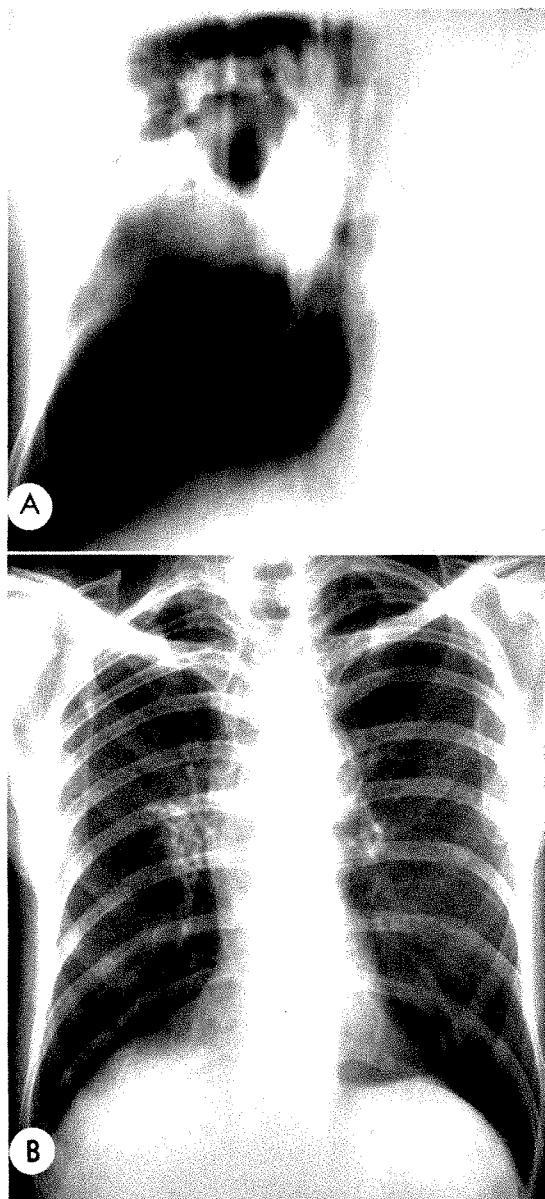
Case IV. Endobronchial and parenchymal Hodgkin's disease. (A) Laminagram showing inflammatory necrosis of parenchymal mass following bronchial obstruction. (B) Complete healing with minor residual fibrosis is demonstrated after a course of roentgen therapy.
